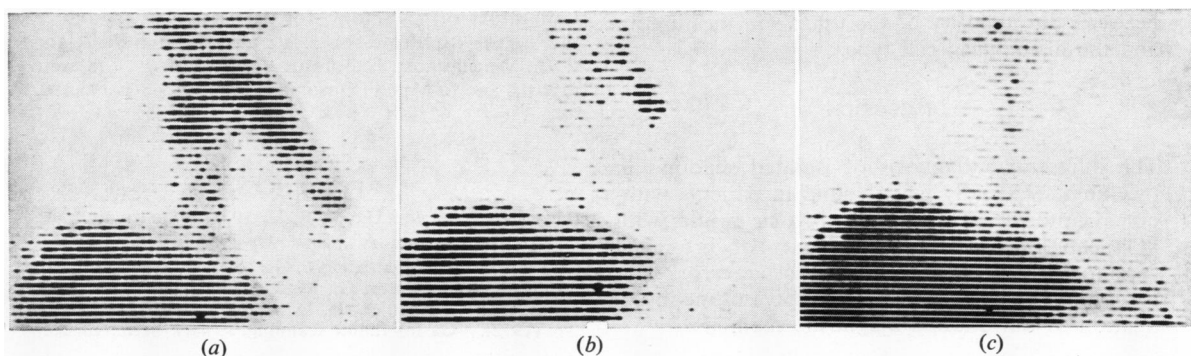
Same patient as in Fig. 3. Frontal scans made three days after injection of 2 mCi gallium-67 citrate: chest radiographs (a) before treatment; (b) after two months' tuberculostatic treatment; (c) after seven months' tuberculostatic treatment.
